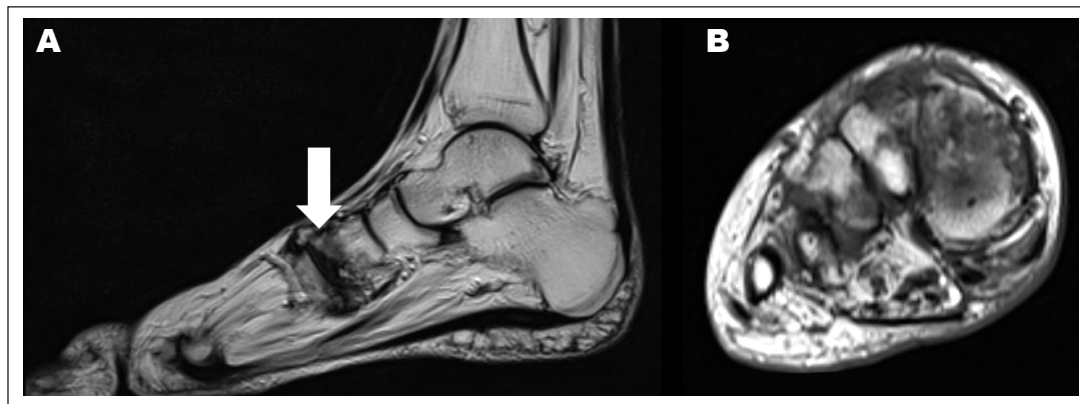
Left foot magnetic resonance image of the second digit, sagittal (A) and axial (B) views. Destructive arthropathy of the common tarsometatarsal joint can be seen resulting in pes planus (solid arrow). There is marrow edema and severe erosive changes in the midfoot consistent with Charcot arthropathy. There is also collapse of the second metatarsal head.
